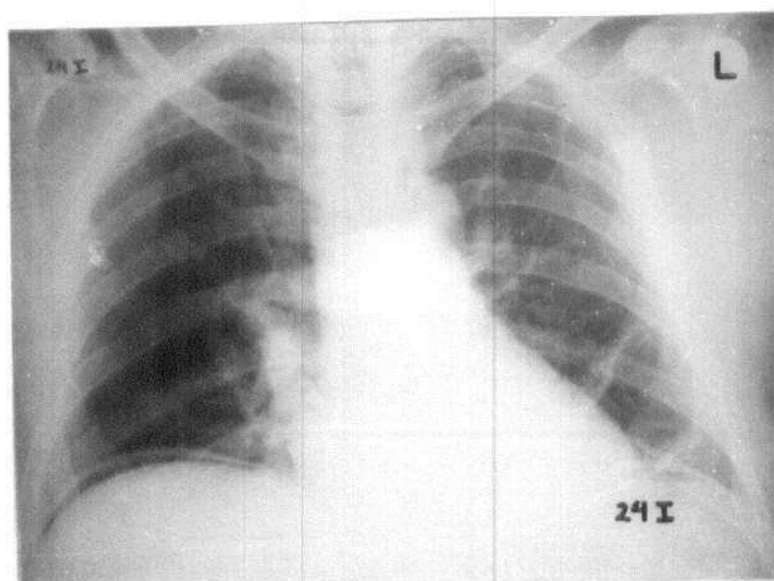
Postoperative chest radiograph for the same patient (24 hours after surgery): showing two left basal curved linear atelectatic bands with bilateral pneumoperitoneum.
